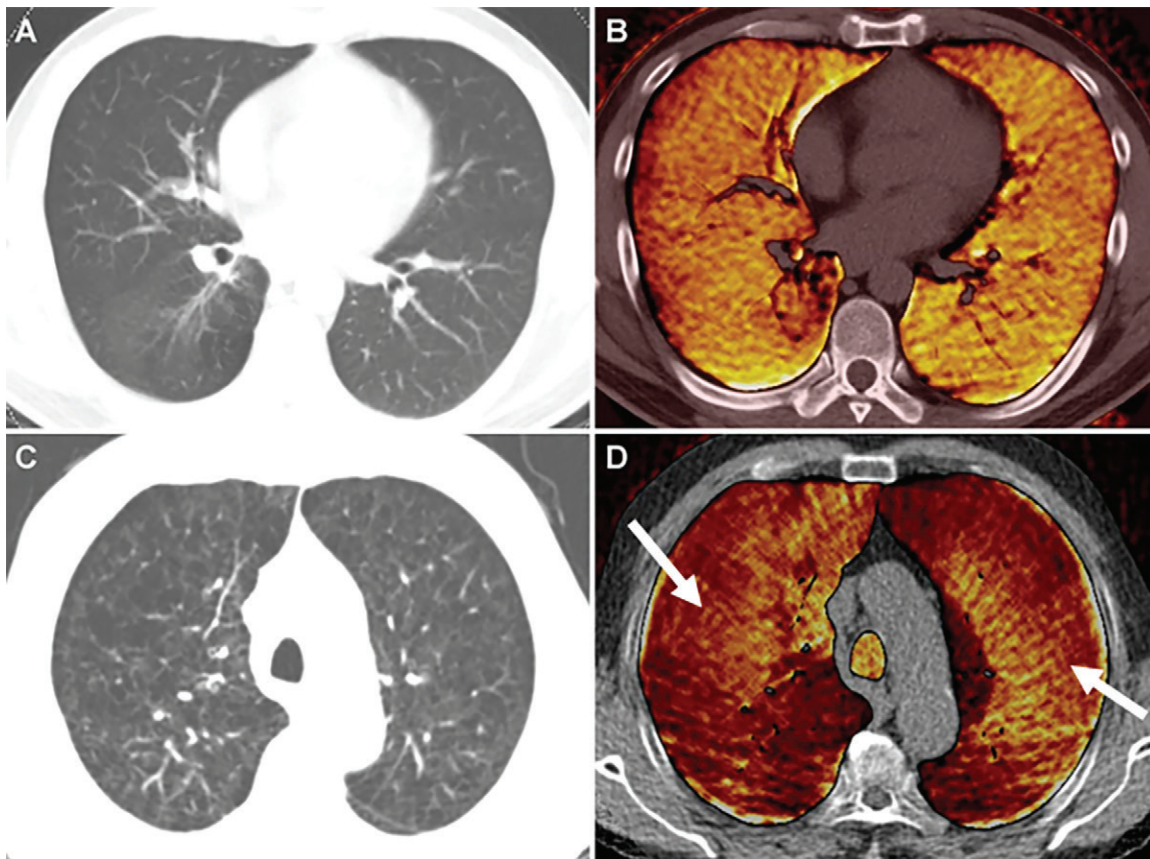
Xenon (Xe) ventilation dual-energy CT in patients with, A, B, chronic obstructive pulmonary disease and mild emphysema and with, C, D, moderate to severe emphysema. A, Dual-energy CT image shows minimal centrilobular emphysema in right lower lobe on axial weighted average image and, B, homogeneous Xe enhancement on Xe ventilation map in both lungs. C, Axial weighted average image shows severe emphysema with bronchial wall thickening in both upper lobes. D, On Xe ventilation map, the inhomogeneously decreased Xe enhancement is identified in both upper lobes, whereas Xe ventilation is relatively preserved in the central areas of both upper lobes (arrows).
